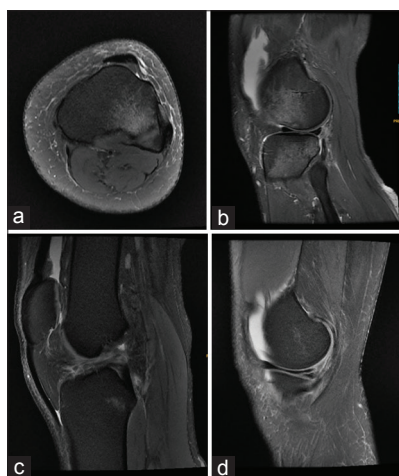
Axial and sagittal PDFS MRI knee images showing (a,b) classical pattern of pivot shift bone marrow edema, involving posterolateral tibia and lateral femoral condyle. (c,d) Complete ACL tear and Grade III tear of posterior horn of medial meniscus in same patient. Mild joint effusion is also present.
